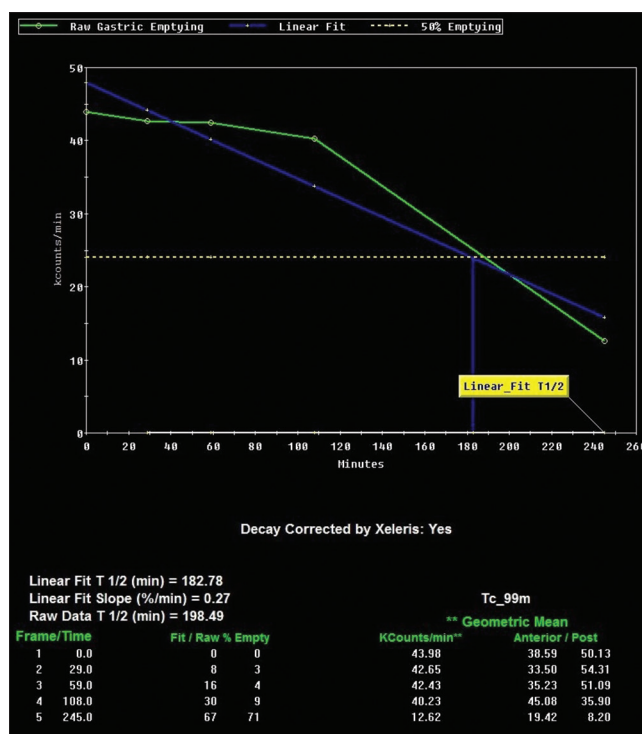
Time activity curve and quantitative parameters of gastric emptying scintigraphy of patient in Figure 3 correspond to delayed gastric emptying (retention at 4 h is approximately 29%)
